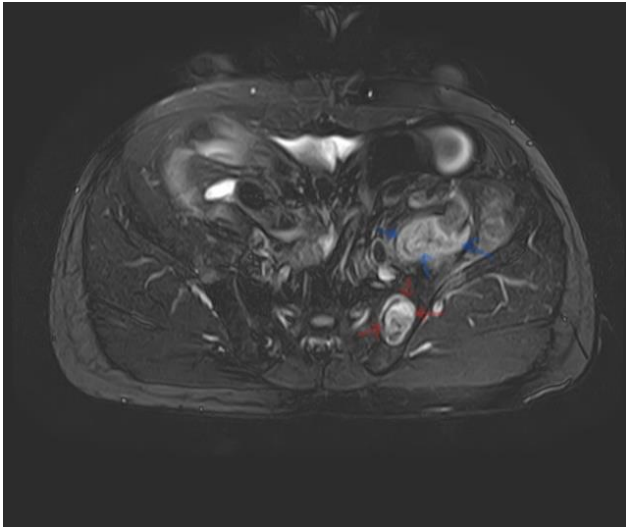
MRI showed extension of abscess draining anteriorly into left iliac muscle.
